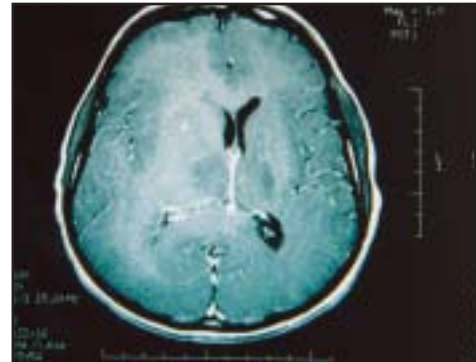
Magnetic resonance image suggesting infiltrative glioma.
